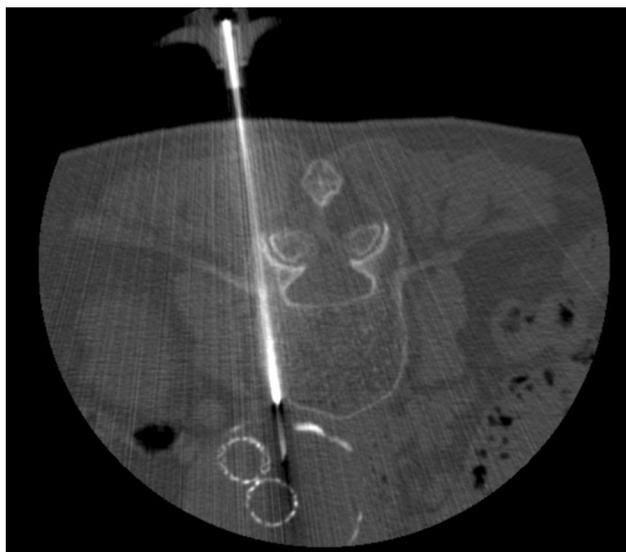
Computed tomography image acquired during the procedure. A 19-G needle is advanced into the aneurysmal sac through a 13-G coaxial bone biopsy needle, which punctures the fourth lumbar vertebra. The fracture is not visible in the fourth lumbar vertebra
